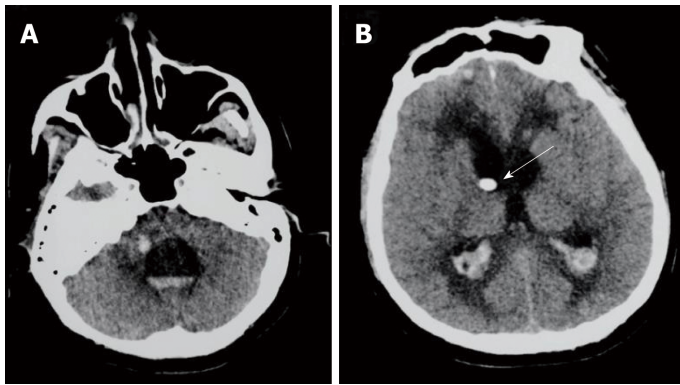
Axial brain computed tomography shows hemorrhage of the right pons (A, white arrow), and gross hydrocephalus and hemorrhage (B, white arrow) on the 14<sup>th</sup> d of administration.
